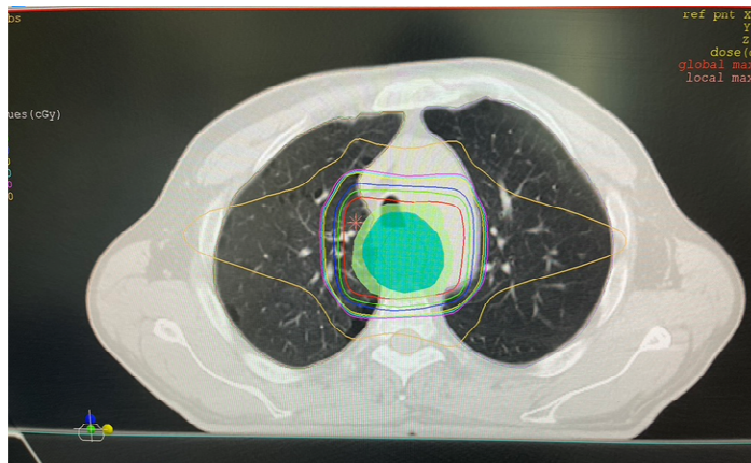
Locally advanced esophageal squamous cell carcinoma of middle esophageal cancer treated with 3DCRT. Axial CT image of the 3DCRT treatment planning showing the isodose distribution.
